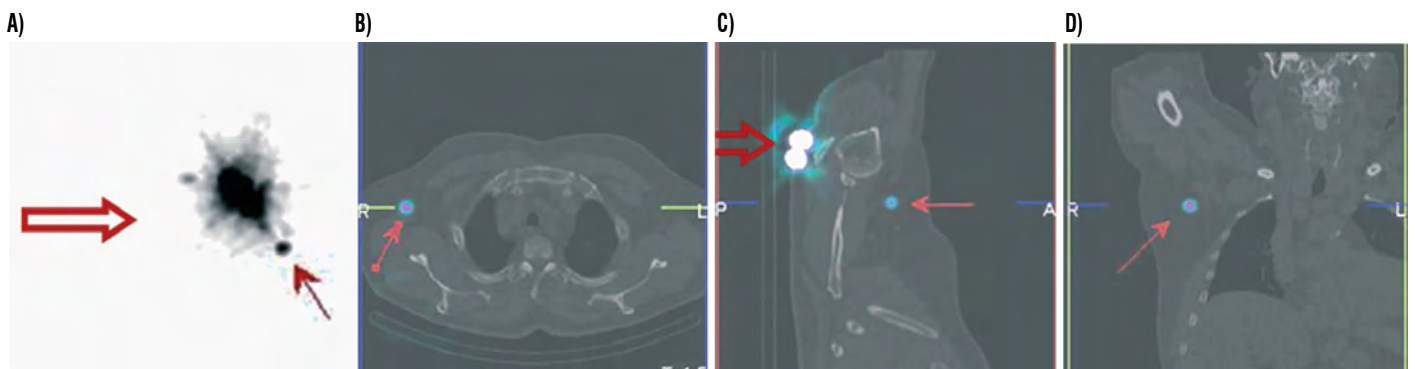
Sentinel node scintigraphy: (A) injection site (open arrow), sentinel node (arrow) on MIP image, (B) hybrid images in transaxial, (C), sagittal and (D) coronal projections
